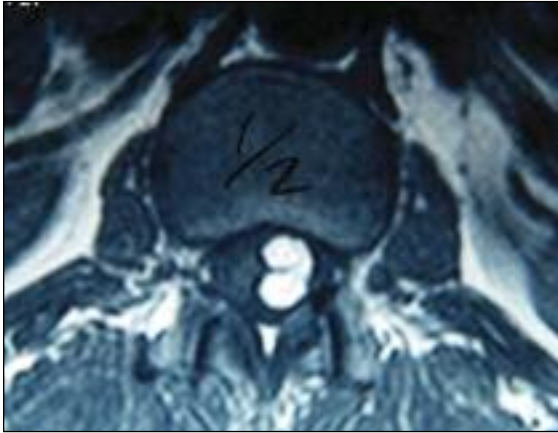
MRI scan at the L2 level (transverse view).
